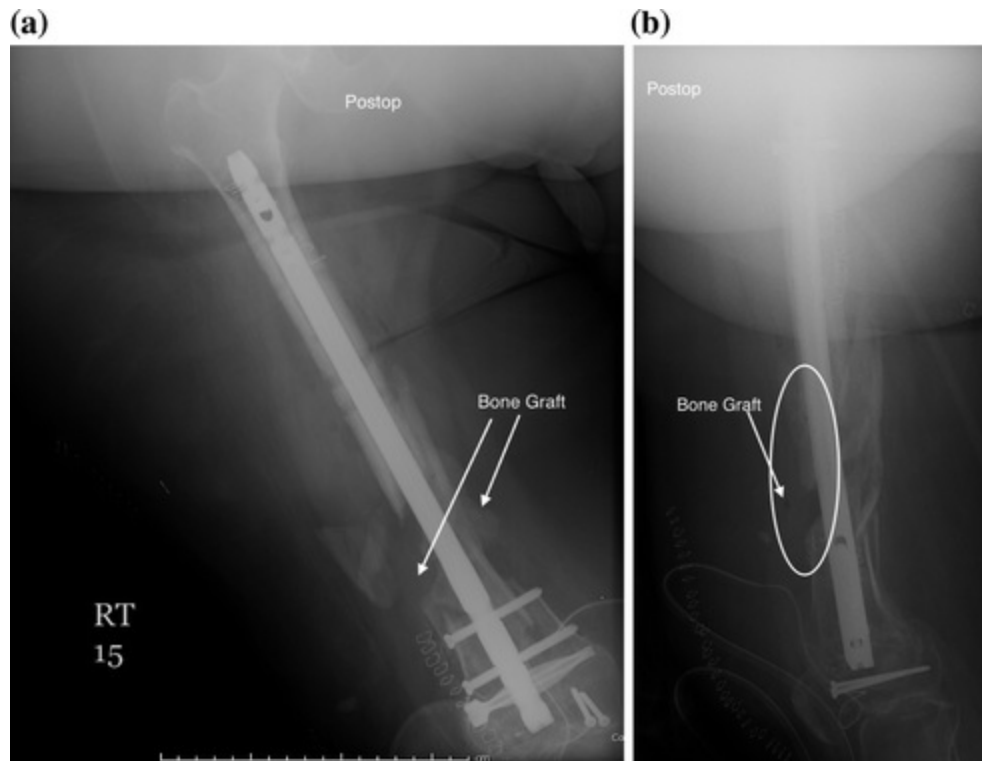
Immediate postoperative a anteroposterior and b lateral radiographs of the right femur showing stabilization of the nonunion site with a retrograde nail and placement of the bone graft
